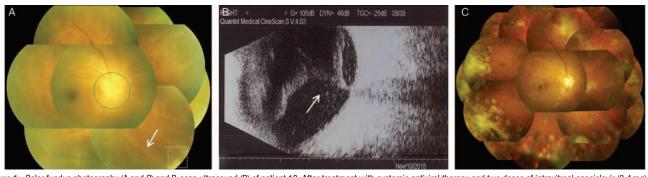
Color fundus photography (A and C) and B-scan ultrasound (B) of patient 18. After treatment with systemic antiviral therapy and two doses of intravitreal ganciclovir (0.4 mg), her fundus (A) still presented with severe vitritis, optic nerve edema (green circle), occlusive retinal arteritis (arrow) and periretinal necrotizing retinitis (rectangle); B-scan ultrasound (B) revealed vitreous inflammatory opacity and tractional retinal detachment (arrow). The patient then received PPV combined with silicone oil tamponade. Her visual acuity at the last visit was 20/100 with retinal reattachment and necrotic lesion regression (C).
